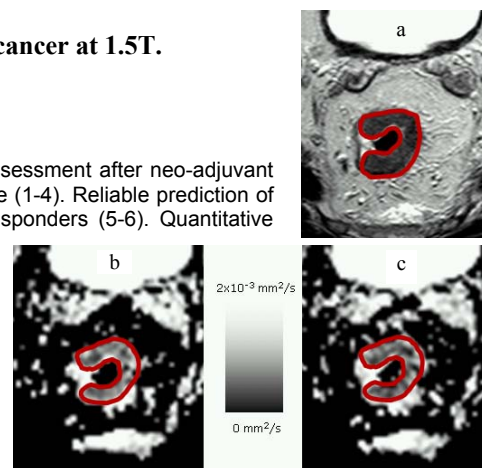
T2 Weighted image (a) and ADC maps (b / c) of one MRI session. The rectal tumor is delineated in red.
